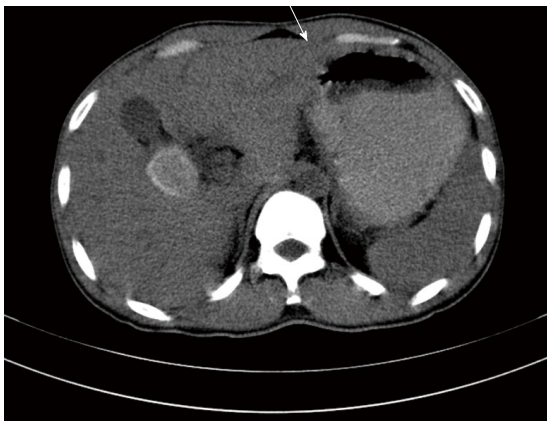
Abdominal computed tomography scan showing pyloroantral thickening and distended stomach.
